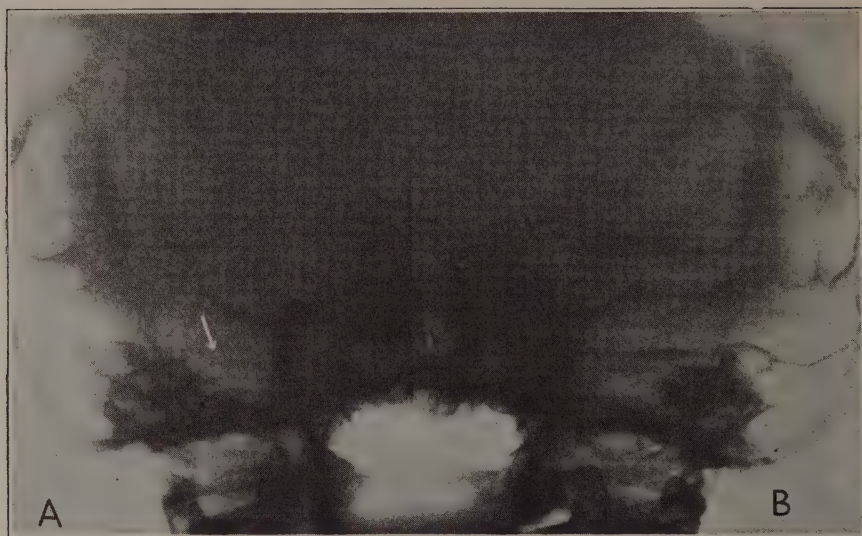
(*Case 8*). Roentgenogram taken before the operation. Note complete loss of outline and definition of the area of the apex tip as compared with that on the uninvolved side. The patient was in the Stenver position.
